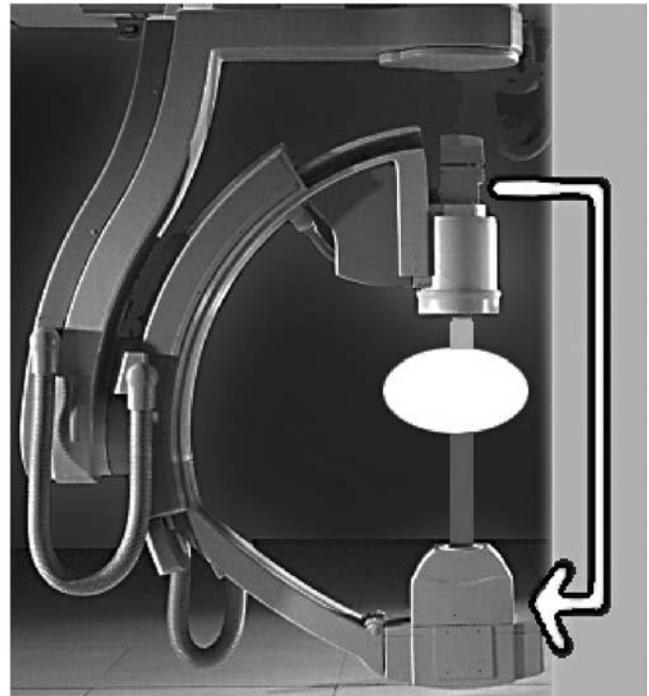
Patient size profoundly affects patient dose. Fluoroscopic systems continuously adjust x-ray output to account for differences in patient size and beam angulation. This is accomplished by using feedback circuits that maintain constant image receptor dose by adjusting the x-ray tube's electrical inputs. Skin dose will double for every 4- to 6-cm increase in path length through the patient. (Photo of gantry courtesy of Philips.)
